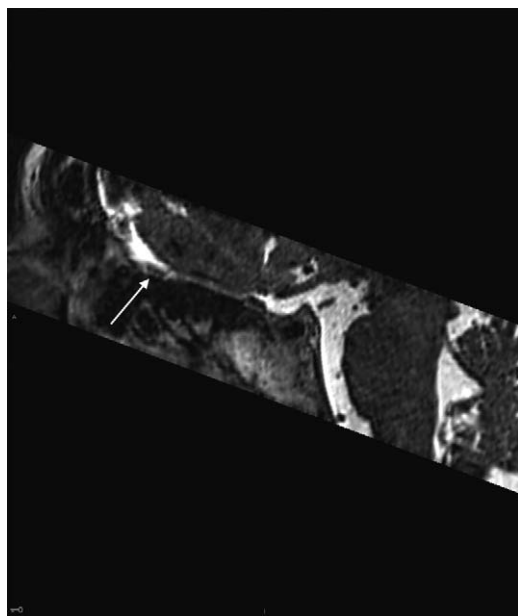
Sagittal 3T MRI high-resolution T2 image with thickened clumped left olfactory nerve filia (white arrow).
